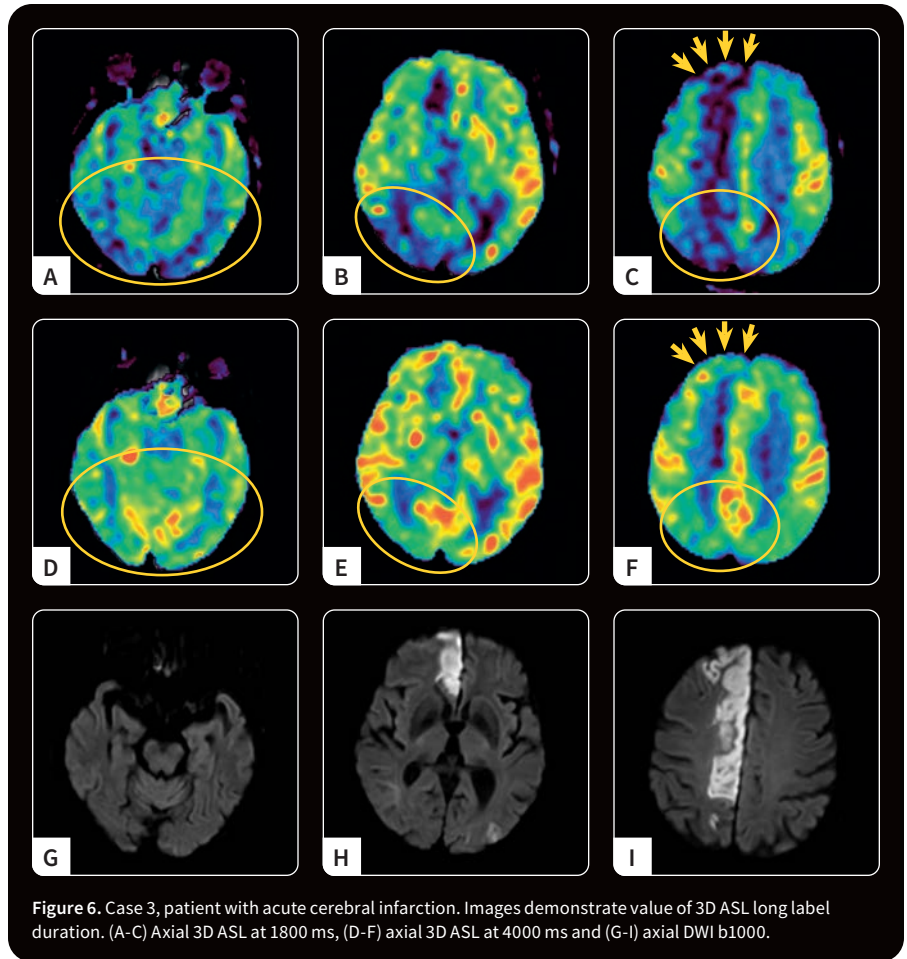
Case 3, patient with acute cerebral infarction. Images demonstrate value of 3D ASL long label duration. (A-C) Axial 3D ASL at 1800 ms, (D-F) axial 3D ASL at 4000 ms and (G-I) axial DWI b1000.
